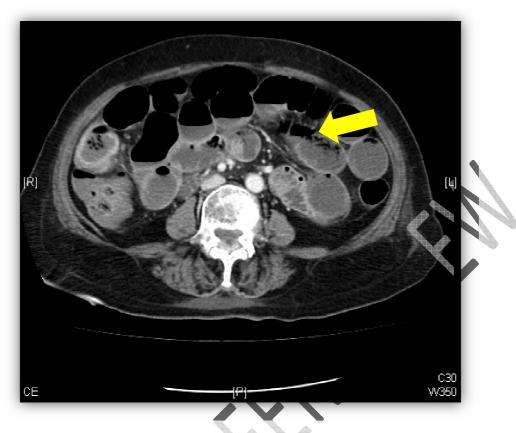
Computed tomography scan of Abdomen and Pelvis showing a 15cm long ischaemic distal jejunal segment with adjacent extraluminal gas
